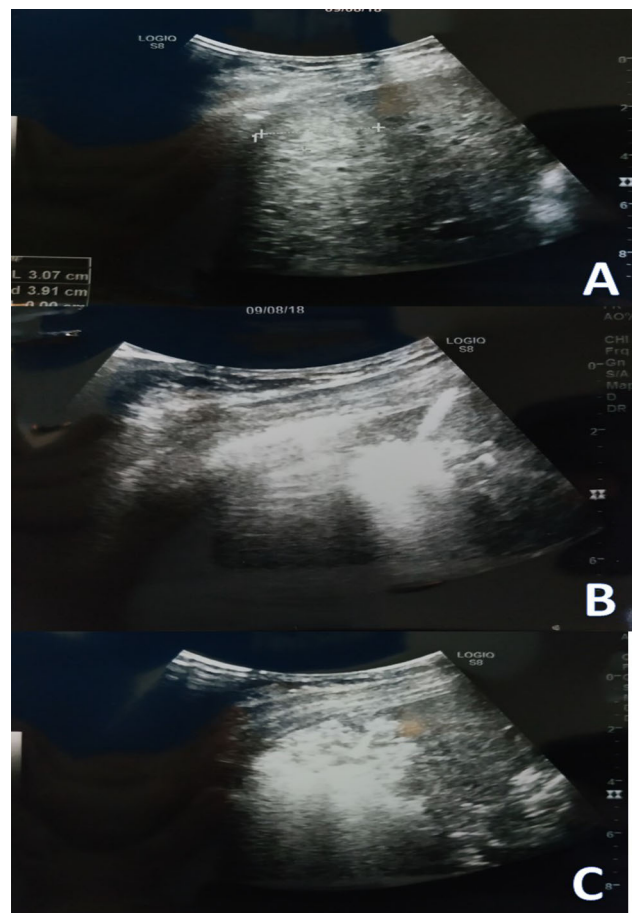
Ablation Method in a 41 year old male patient with Primary Hepatocellular Carcinoma secondary to Chronic Hepatitis B. Figure 1-A depicts the sonographic evaluation done prior to MAT. Figure 1-B presents the development of hyperechogenicity, representing the evolution of an ablation zone. Figure 1-C shows the hepatocellular tumor post-microwave ablation presenting as a hyperechoic area with distinct borders.
